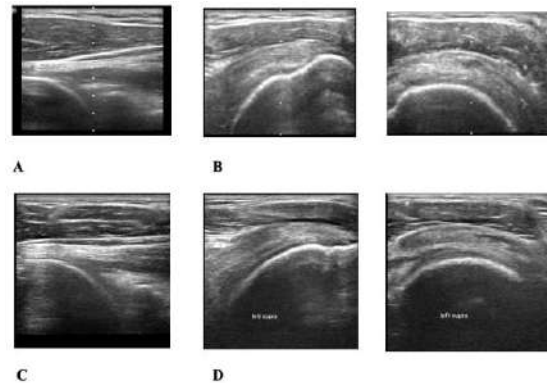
Initial Musculoskeletal Ultrasound of the Left Shoulder A. Posterior Joint B. Supraspinatus in Long Axis and Short Axis Views
